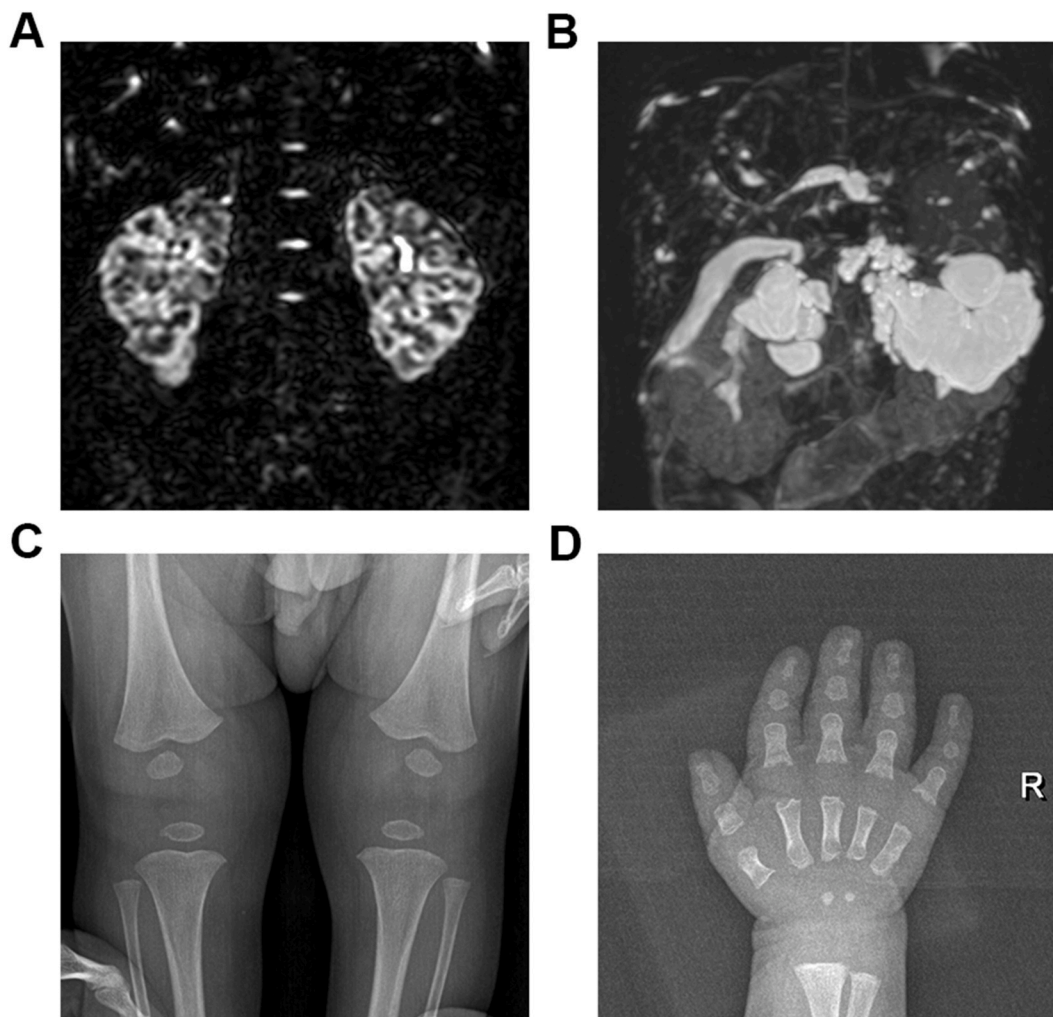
Phenotype of the kidneys and images of the extrarenal manifestations of the patient. (A) Abdominal magnetic resonance imaging demonstrated bilateral kidneys were enlarged with diffuse microcysts. (B) Liver and pancreas cysts, and focal dilatation of the intrahepatic bile ducts. (C) Digital radiography of both knees showed no definite structural abnormalities. (D) X-ray revealed the temporary calcified zone at the distal end of the metacarpals, metacarpals and phalanges were short and broad.
